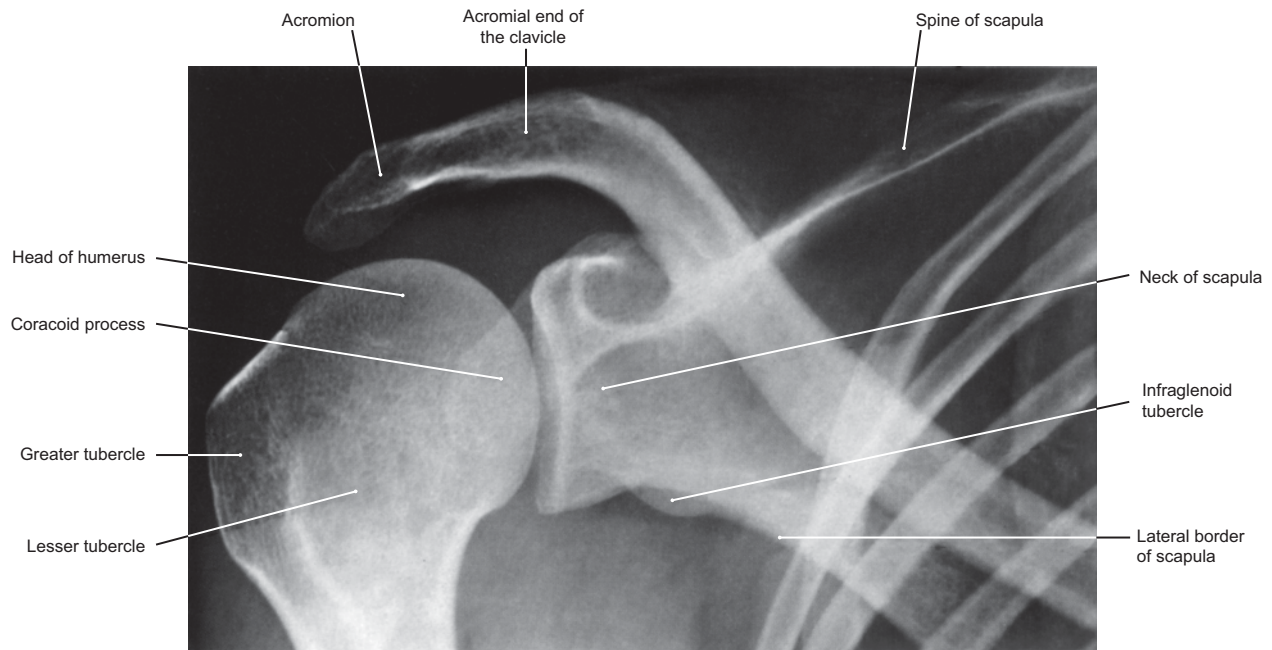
Radiograph of the Right Shoulder Joint (Humerus Alongside the Body)
